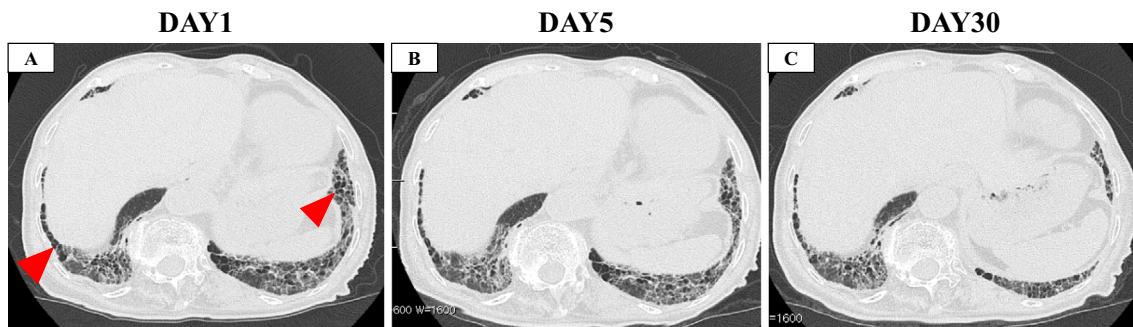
Computed tomography images. A: On the day of admission to our hospital. B: On the day of the initiation of steroid therapy (five days after admission). C: Two weeks after the initiation of steroids. Red arrows show newly observed ground-glass opacity (GGO), and red arrow heads show honeycomb.
